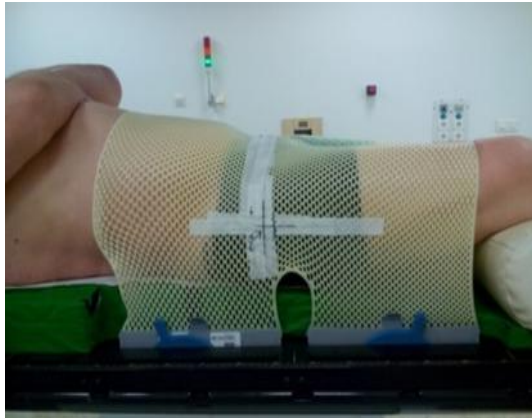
Topometric CT scanning in supine and prone position
